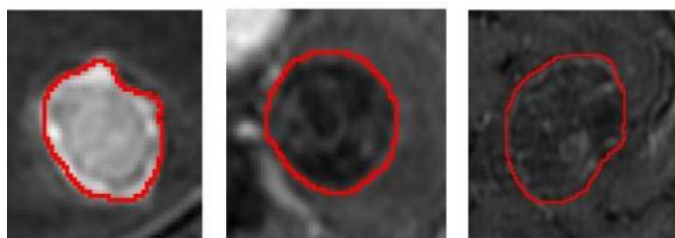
MRI Brain Tumor image various Appearances
